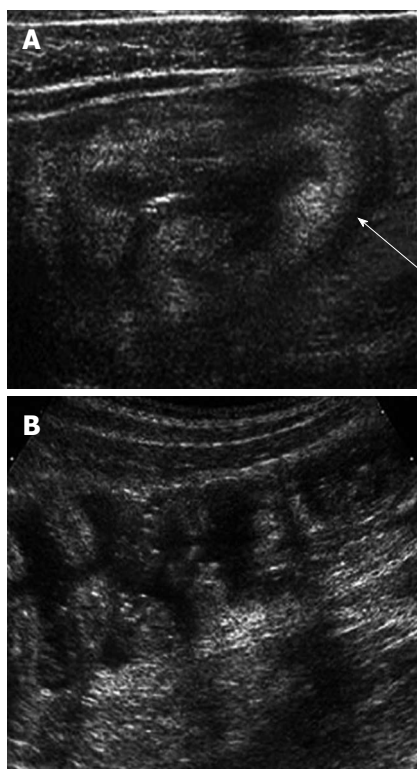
Bacterial enteritis. A: Ultrasound showing marked wall thickening of the cecum (arrow) in a child with right lower quadrant pain, which returned to normal; B: 4 d later. Stool cultures were positive for enterohemorrhagic *Escherichia coli*.
